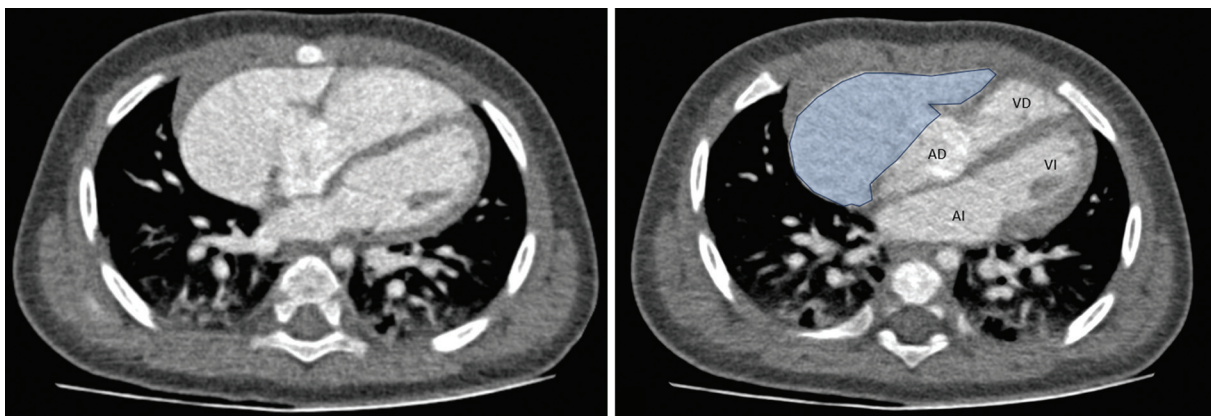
Computed tomography angiography of the newborn. Axial scan. Right atrial appendage aneurysm (blue).
